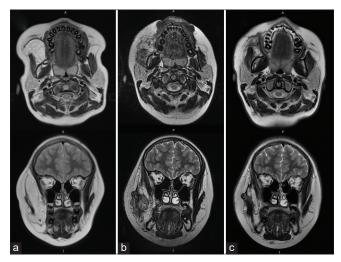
T2-enhanced magnetic resonance images in the axial and coronal sections, where the changes were observed during the care of the ablation, are shown here sequentially. (a) A basal study shows a lesion with intensity similar to that of fatty tissue in the right masticatory space that displaces the masseter muscle. This lesion extends toward the zygomatic and pterygomaxillary fossa regions, involving an increase in the volume of said area prior to ablation. (b) Control study 5 months after ablation (c) Same sequences 1 year and 9 months after ablation: Note the decreased volume of the tumor and the presence of hypointense fibrous scar tissue.
